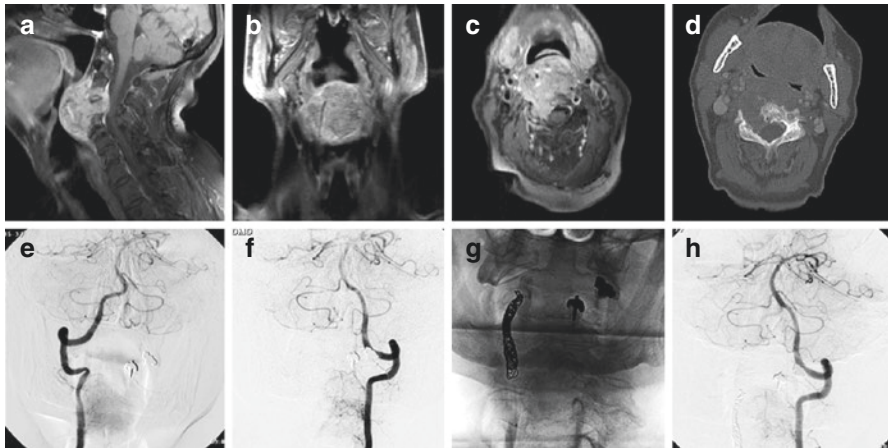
Preoperative therapeutic vertebral artery occlusion in a patient suffering from a chordoma of C2. Post-contrast MR images (a, b, c) show a chordoma of C2-C3-C4 extending to the anterior and paraspinous soft tissues. Non-enhanced CT (d) better defines the erosion of the vertebral bodies. Patient undergoes a preliminary DSA (e, f), showing that both vertebral arteries, of good caliber, reach the basilar artery, thus allowing occlusion of the right one. Frontal single shot radiographs (g) and left vertebral artery selective angiogram (h) demonstrate the occlusion with platinum coils of the extracranial vertebral artery with good supply of posterior fossa circulation from left vertebral artery
